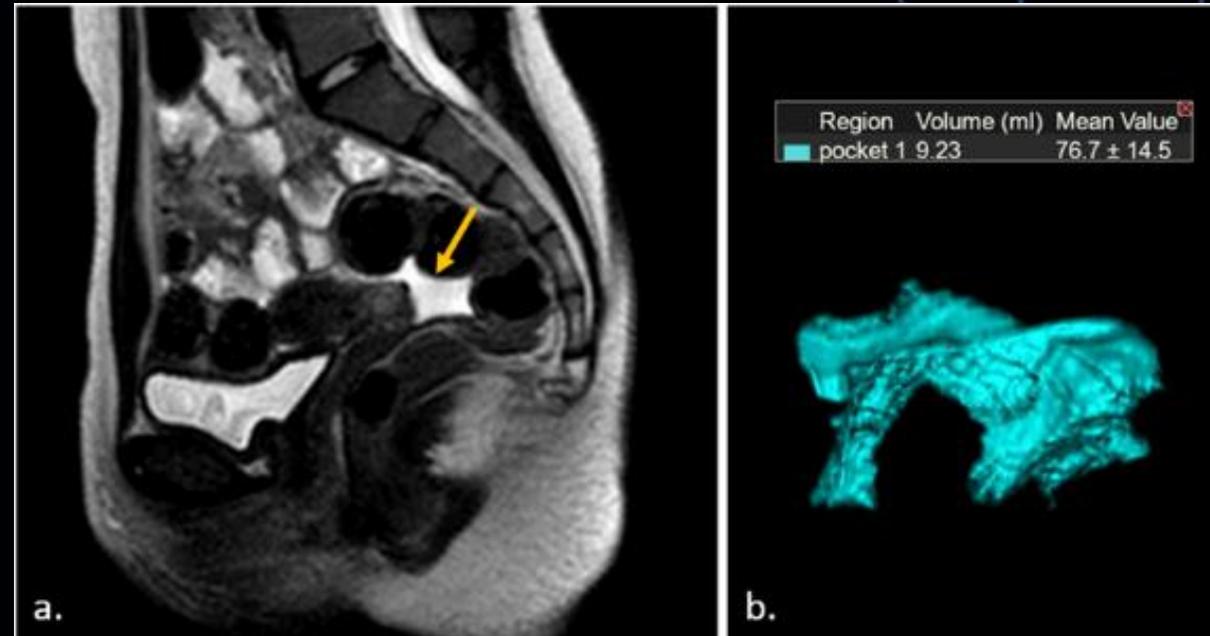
(a) Sagittal T2-weighted MRI shows free fluid in a 15-year-old female (arrow). (b) Corresponding 3 dimensional image shows a 9.23 mL pocket of fluid in a same individual.
